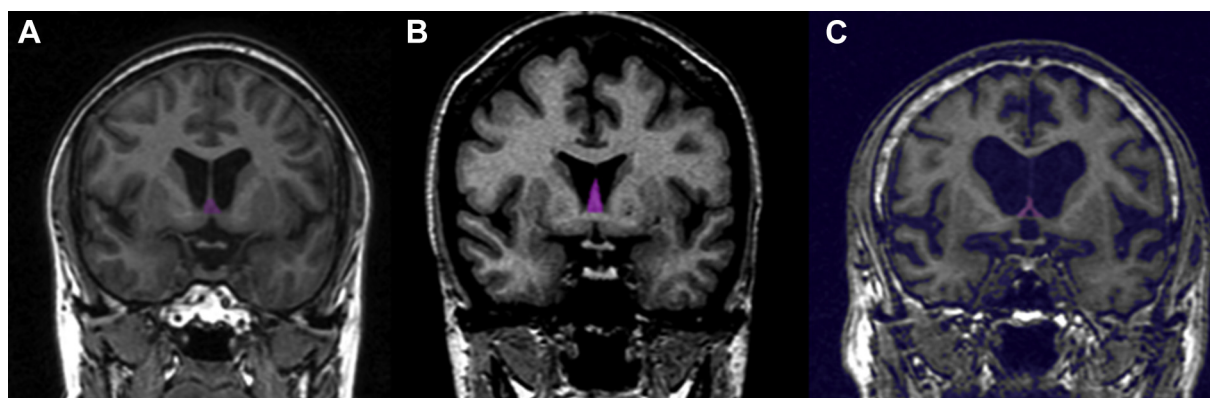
Examples of segmented septal nuclei (pink shading) on coronal T1 MRI at the level of the anterior commissure in (A) a normal control, (B) a subject destined to develop AD in the future but clinically normal at the time of scanning, and (C) a patient with current MCI/AD. Note larger septal region in the future AD subject and virtually no septal gray matter in the current MCI/AD patient. Abbreviations: AD, Alzheimer's disease; MCI, mild cognitive impairment; MRI, magnetic resonance imaging. (For interpretation of the references to color in this figure legend, the reader is referred to the Web version of this article.)
